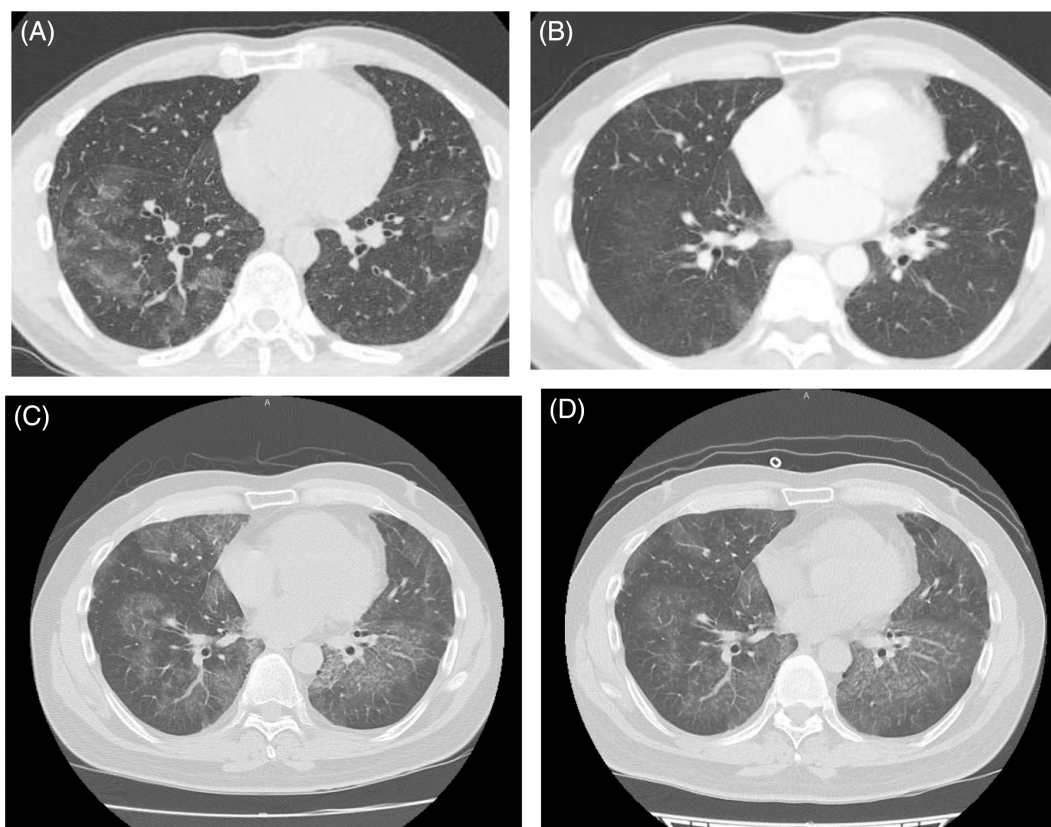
(A) Chest computed tomography (CT) showed bilateral diffuse ground-glass opacities. (B) After 12 months of treatment with a corticosteroid, the ground-glass opacity gradually improved. (C) After 16 months of corticosteroid treatment, the ground-glass opacity worsened after reducing the steroid dose. (D) After increasing the corticosteroid dose and adding an immunosuppressive agent, the chest CT scan showed worsening of ground-glass opacity.
